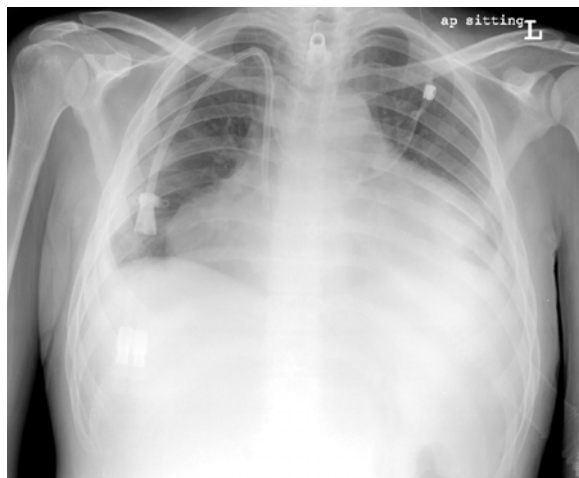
Chest radiograph (AP view) demonstrating small bilateral pleural effusions associated with a large pericardial effusion in a lupus patient presenting with pleuropericarditis.
